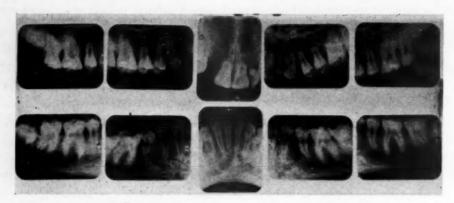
X-rays of the patient, Case 2, Oct. 9, 1940.
